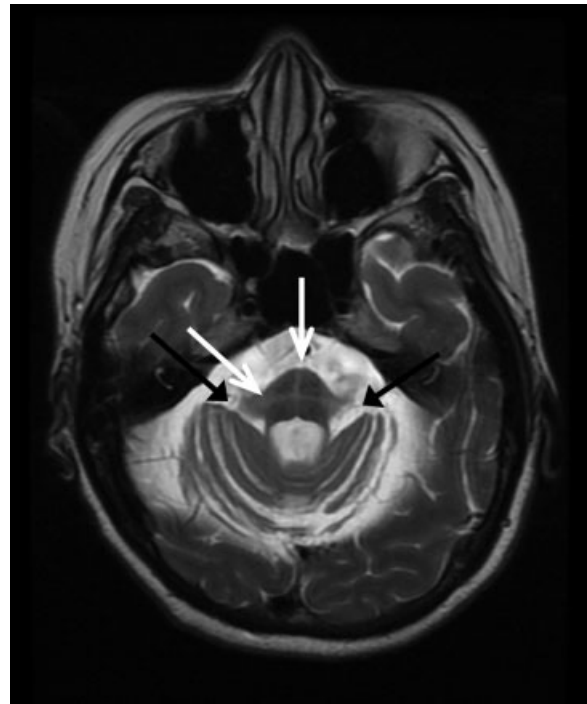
T2-weighted axial MRI of the pontine-middle cerebellar peduncle (MCP) junction in a patient with MSA-C. Black arrows point to MCP hyperintensity. White arrows point to the hot cross bun sign in the pons. Bilateral cerebellar hemisphere atrophy is also present.
